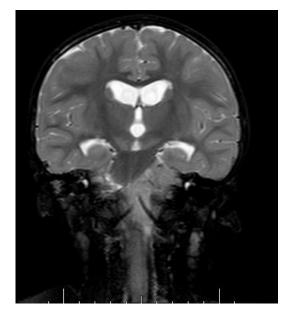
Coronal MRI T2- weighted slice showing arterial involvement by the tumor.
